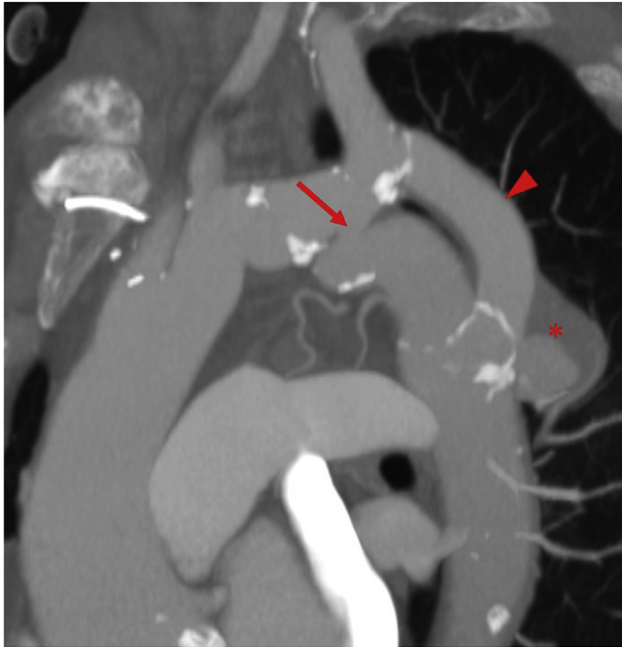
Preoperative computed tomography (CT) reconstruction showing coarctation of the aorta (AC) with a short residual isthmus (arrow) at the lower part of the aortic arch, the previous bypass (arrowhead) with a distal anastomotic pseudoaneurysm (asterisk).
